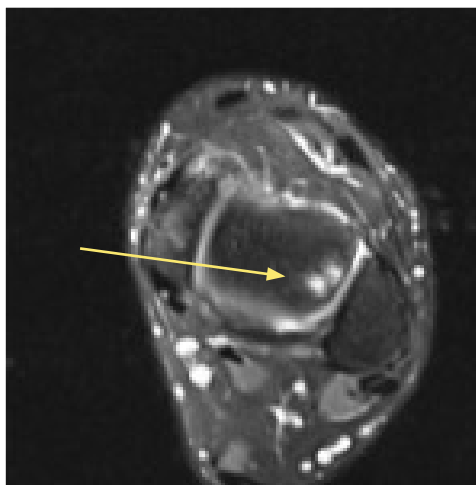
Pre-op T2 Axial MRI showing OCD lesion
